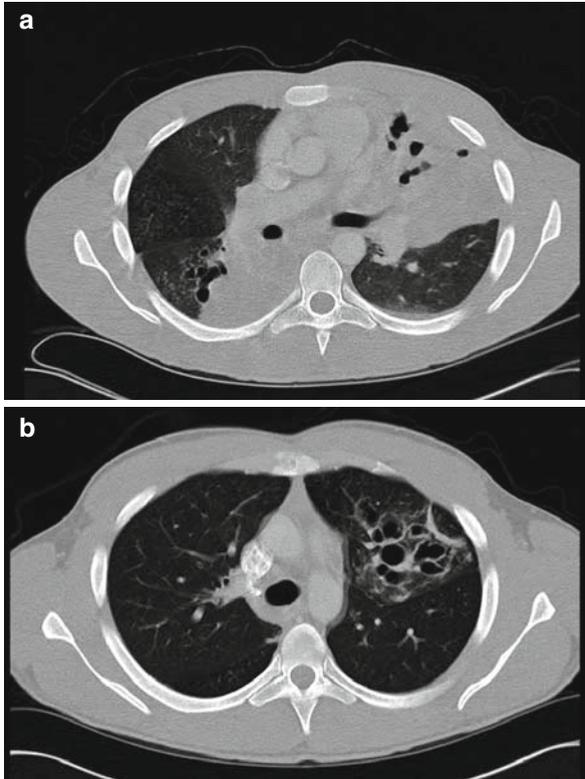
(a) Chest computed tomography (CT) scan showing segmental atelectasis of the *left upper* lobe and *right lower* lobe with bronchiectatic changes. After treatment with systemic steroids and an antifungal agent, the chest CT scan showed resolution of the atelectasis with residual bronchiectasis in the *left upper* lobe (b)
